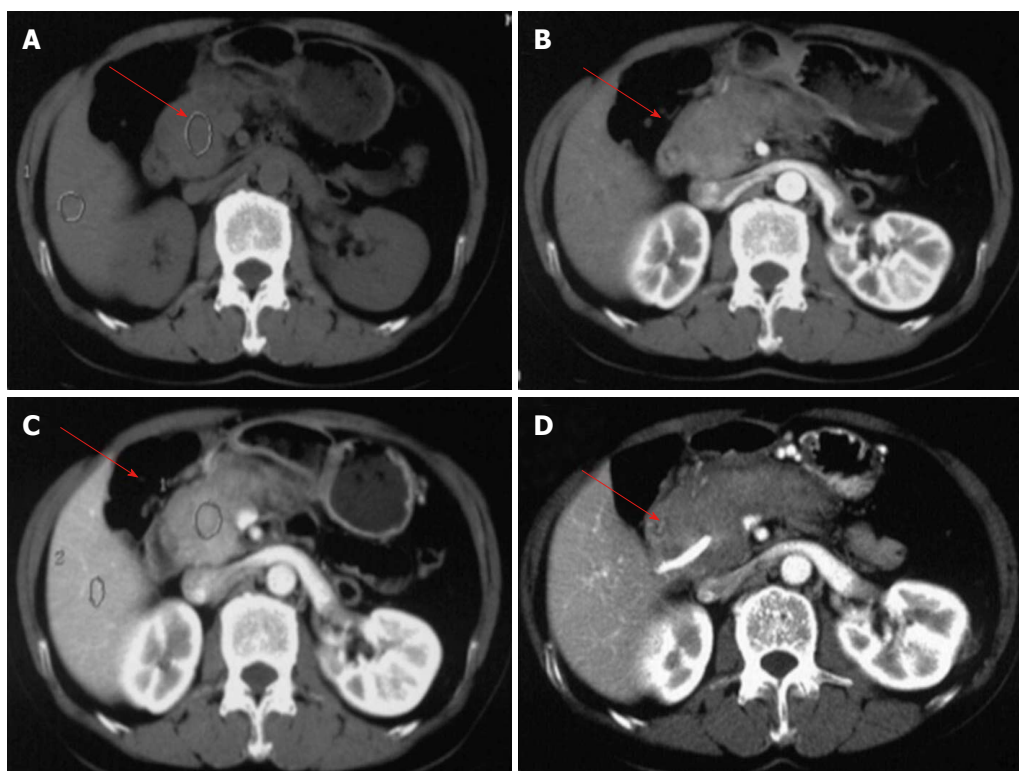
Involvement of pancreas and bile duct. Abdominal computed tomography (CT) showed enlargement of the head of the pancreas. A: Plain scan showing the enlargement of the head of pancreas; B: Arterial phase showed a slight homogeneous enlargement; C: Portal phase showed an obvious enlargement of the pancreas; D: CT showed the bile duct stricture.
